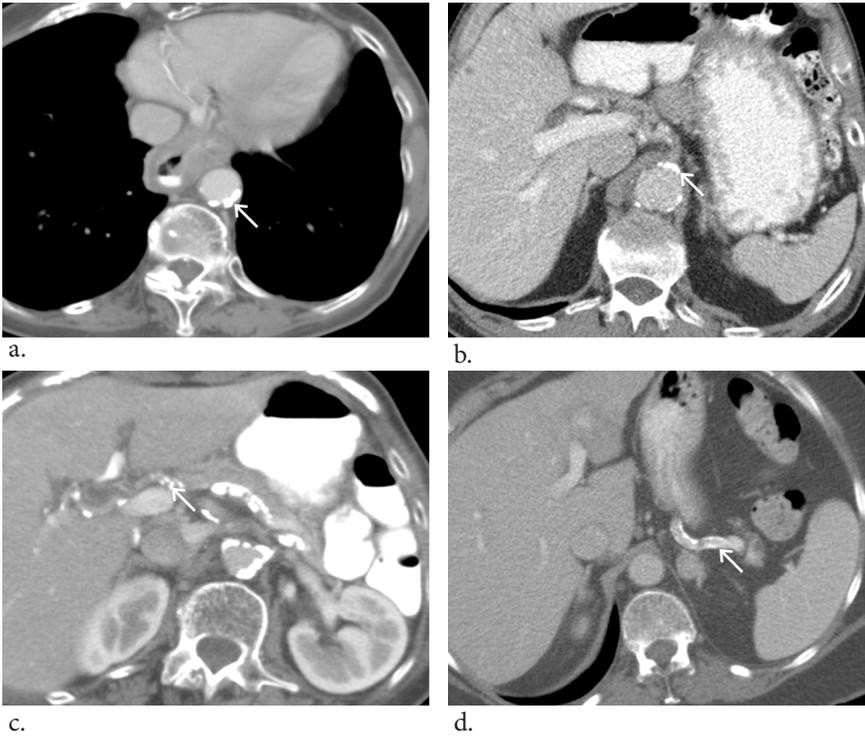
Findings of calcifications on preoperative transverse CT images obtained in four esophageal cancer patients. (a) Image shows descending aorta with multiple calcified foci (*white arrow*). An aortic calcification score of 2 was assigned as CT demonstrated 21 foci in the predefined length of the aortic wall with 8 foci extending over ≥ 3 transverse sections. This patient experienced anastomotic leakage on postoperative day 5. (b) Image shows calcifications of celiac axis (*white arrow*) that extended over three transverse sections with a maximal cross-sectional diameter of 12 mm. A celiac axis calcification score of 2 was assigned. On the third day after esophagectomy the patient suffered from anastomotic leakage. (c) Image shows calcifications of common hepatic artery (i.e. right post-celiac arteries; *white arrow*). A right post-celiac calcification score of 1 was assigned and anastomotic leakage occurred on postoperative day 5 in this patient. (d) Image shows calcifications of splenic artery (i.e. left post-celiac arteries; *white arrow*). A calcification score of 1 was assigned to the left post-celiac arteries in this patient who did not experience postoperative anastomotic leakage.
